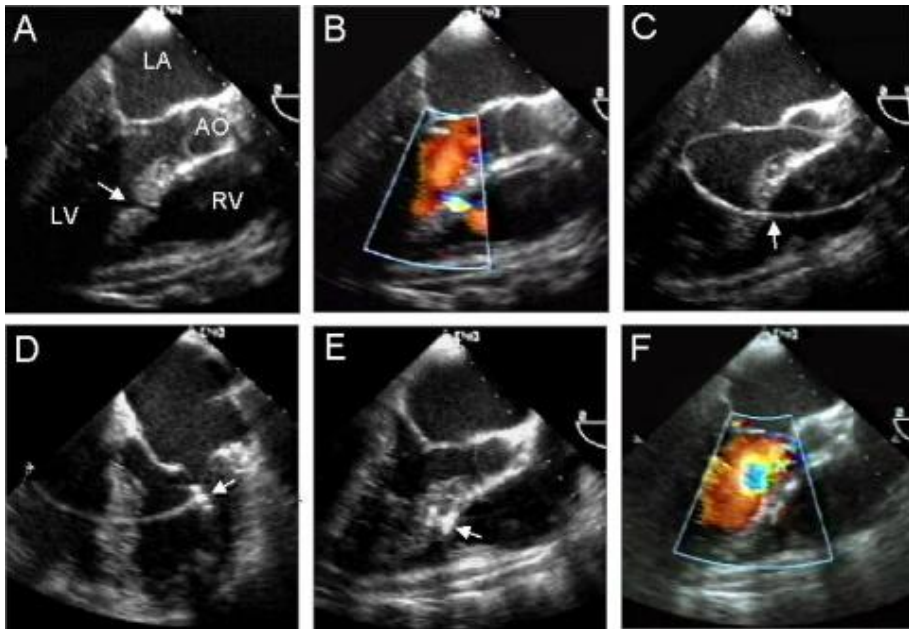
Transoesophagealechocardiography of amidmuscular VSD.
